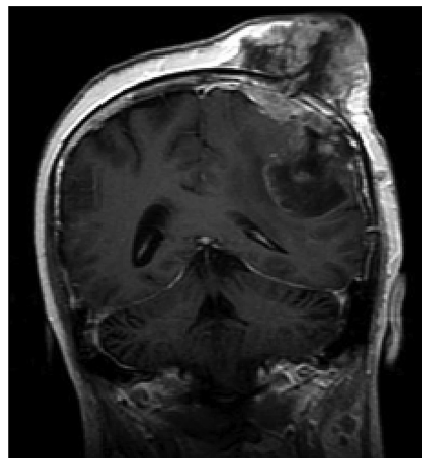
MRI (T2 + contrast) findings in a 50-year-old woman with glioblastoma multiforme. An intracranial tumor is present on the left frontal–parietal area and a large mass with subdural and scalp invasion along the previous surgical site is observed. MRI = magnetic resonance imaging.
